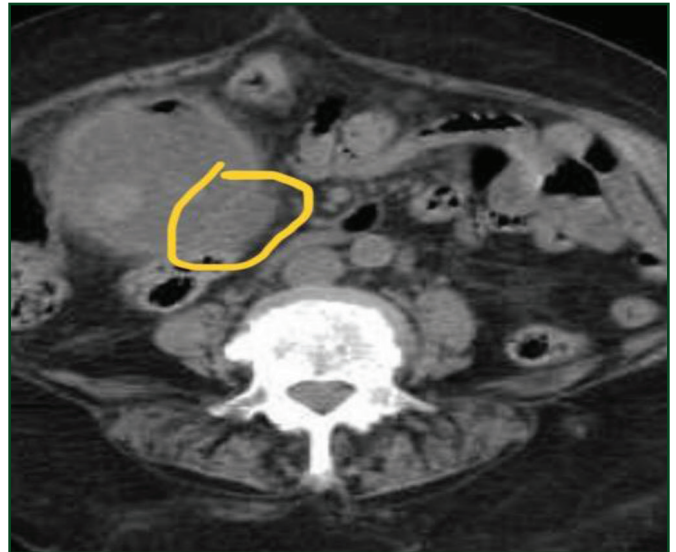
Non-contrast CT image showing yellow circle at this slice shows focal disruption of wall at 3 to 6 o'clock position consistent with impending rupture.
